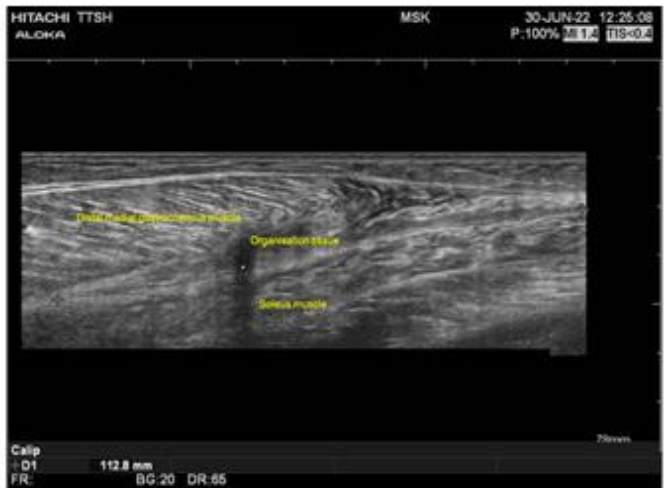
Ultrasound image of Patient A on final review visit
